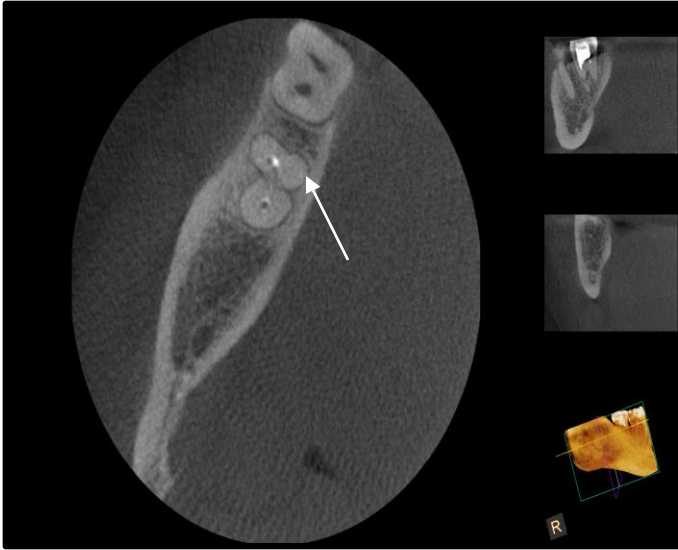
Axial CBCT slice showing secondary dentin formation on mesio lingual root in the coronal third of the root
